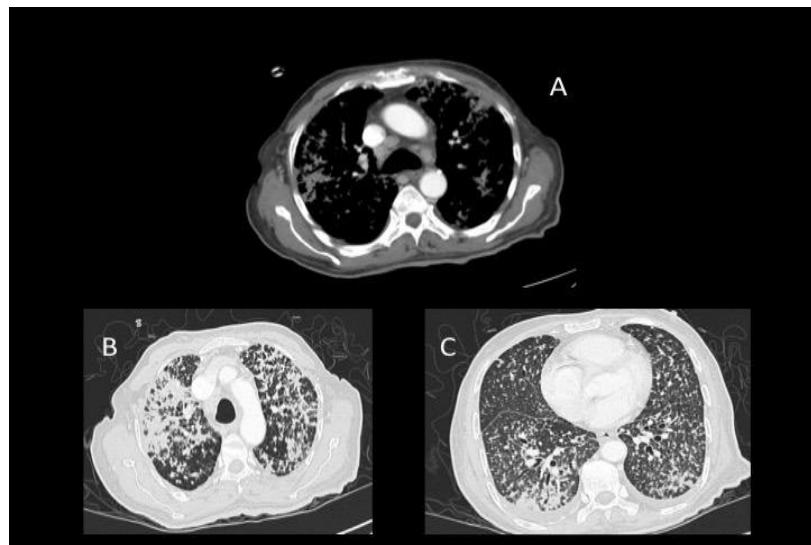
4B & 4C: CT chest (mediastinal and lung algorithms) confirms the presence of innumerable small pulmonary nodules, which have a centrilobular predilection and dependent changes are also present.
